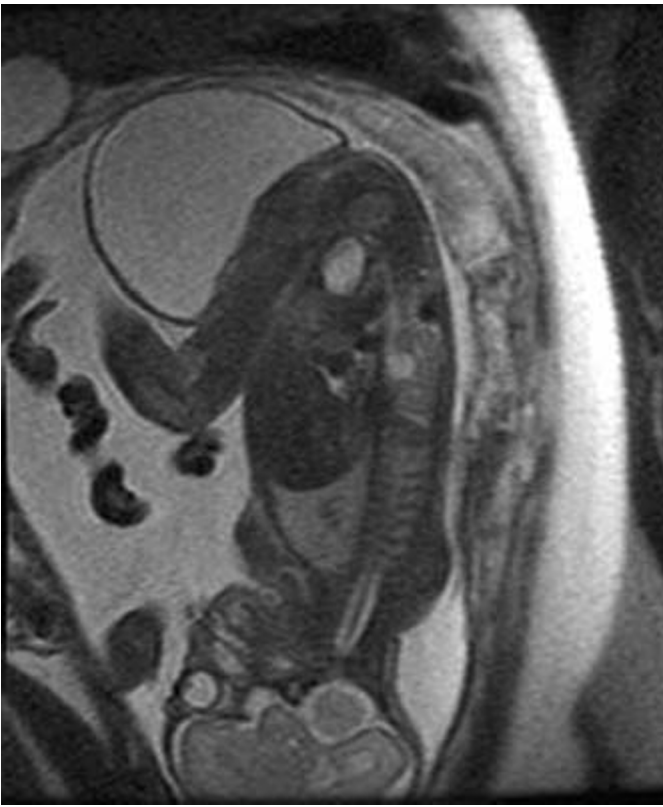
MRI (T2 weighted images) of the maternal pelvis depicting a large cystic mass arising from the sacrococcygeal region of the fetus suggestive of a sacrococcygeal teratoma
